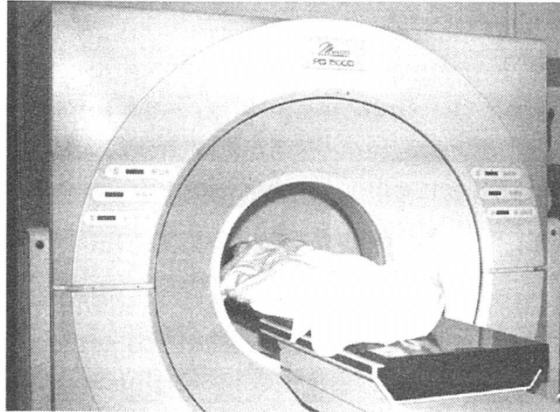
Marconi Medical System PQ5000 continuous spiral CT scanner.
